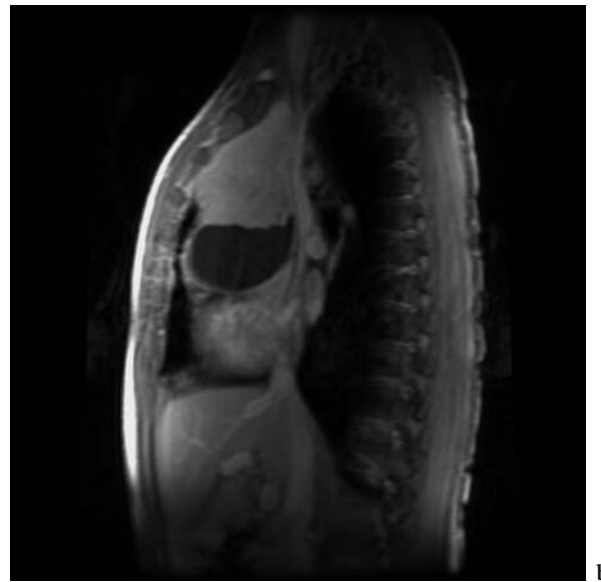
Non-Hodgkin's lymphoma. a Sagittal contrast-enhanced and c coronal enhanced 2D MPR images are compared with b contrast-enhanced sagittal and d coronal gradient-echo images. Both images show well the complex solid and cystic components of this large mass, but the CT reconstructions show to much better advantage the vessels as they relate to the tumor and show the relationship of the mass to the pericardium much better. e The 3D color-enhanced volume-rendered image shows the solid and cystic components of this mass as well as its relationship to the vessels
